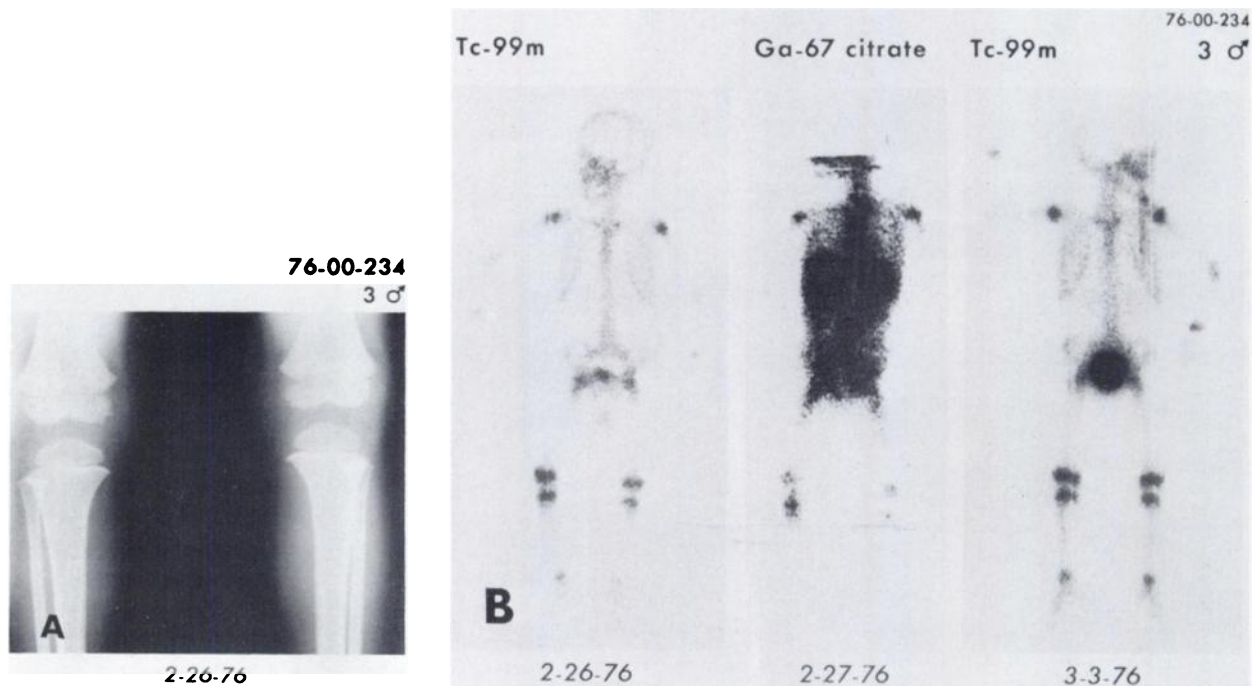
Three-year-old boy with fever and painful, hot right knee. (A) Radiographic examination of knees was normal. (B) Initial Tc-99m HEDP bone scan (2-26-76) demonstrated minimally increased activity in epiphyseal plate areas of right distal femur and proximal and distal tibia. Gallium-67 scan showed disparately increased activity in right proximal tibia. Blood cultures and clinical course confirmed acute hematogenous osteomyelitis. Repeat bone scan (3-3-76) after 4 days of intravenous antibiotics was completely normal.
